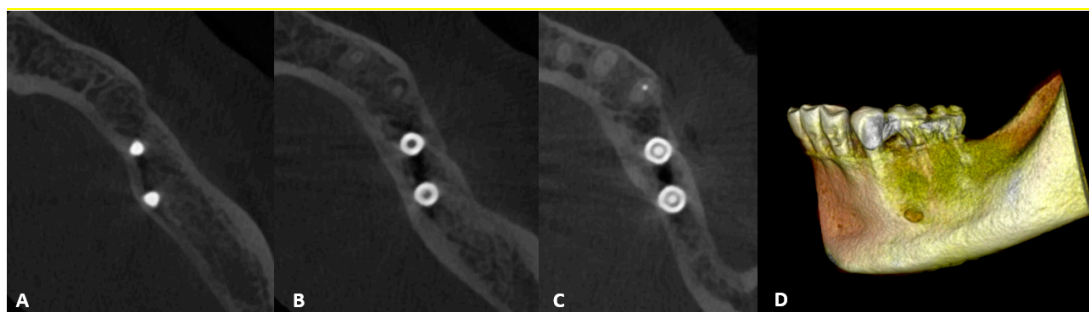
CBCT follow-up at 37 months. (A–C) Axial view from bottom upwards. (D) Three-dimensional rendering (OsiriX) based on CBCT from postoperative check-up at 37 months after regenerative surgery.
